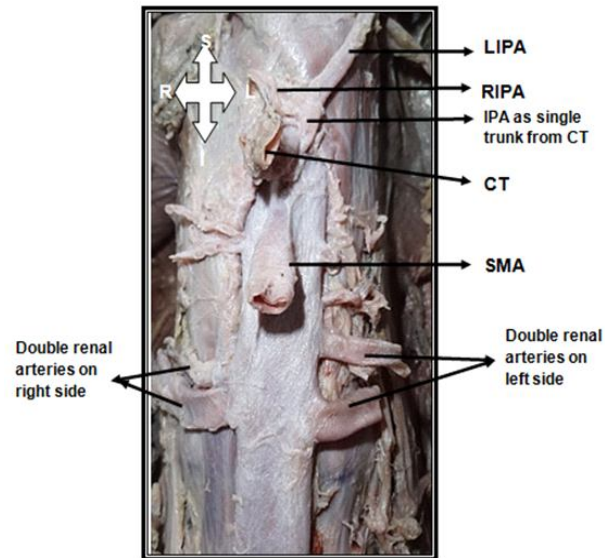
Origin of IPA as single trunk from CT
